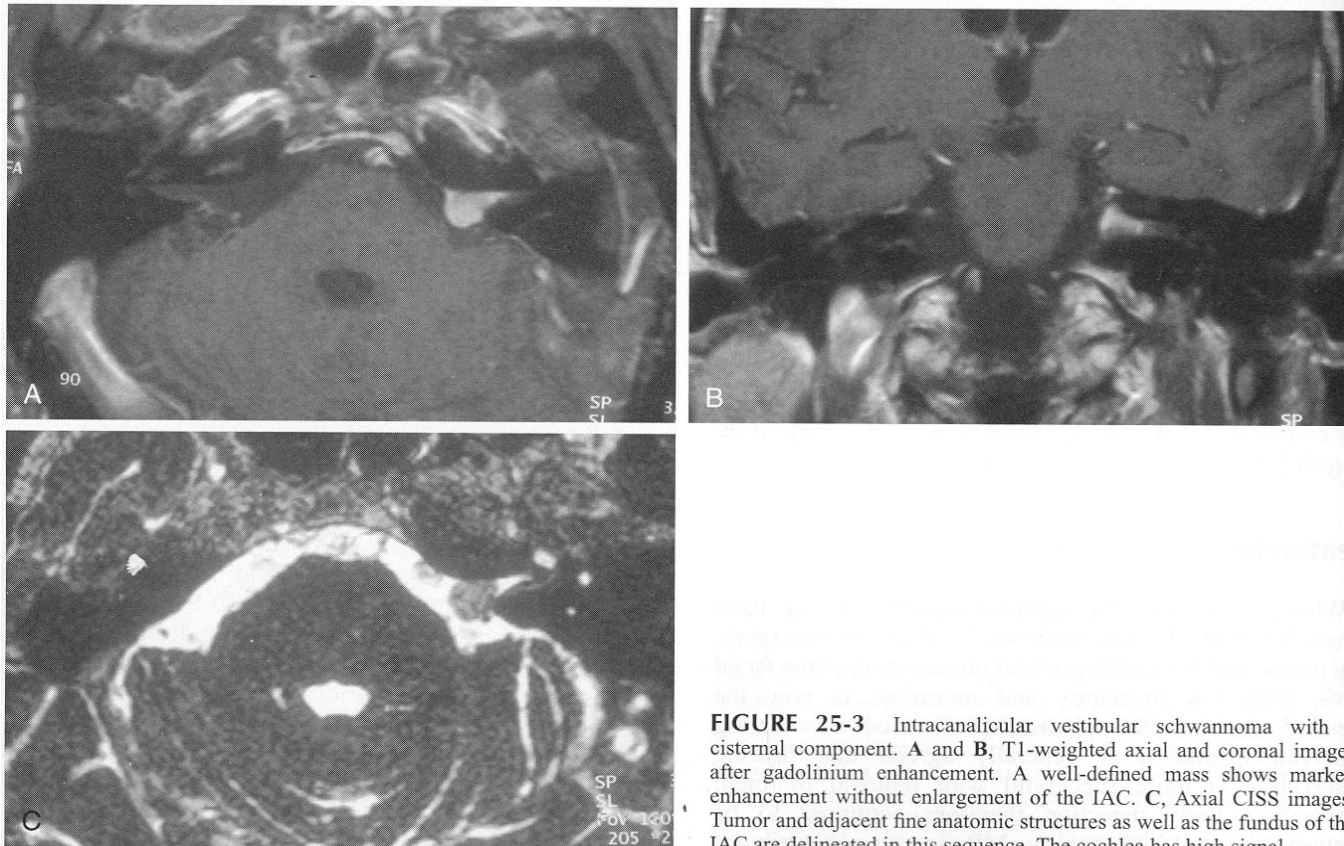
Intracanalicular vestibular schwannoma with a cisternal component. A and B, T1-weighted axial and coronal images after gadolinium enhancement. A well-defined mass shows marked enhancement without enlargement of the IAC. C, Axial CISS images. Tumor and adjacent fine anatomic structures as well as the fundus of the IAC are delineated in this sequence. The cochlea has high signal.
